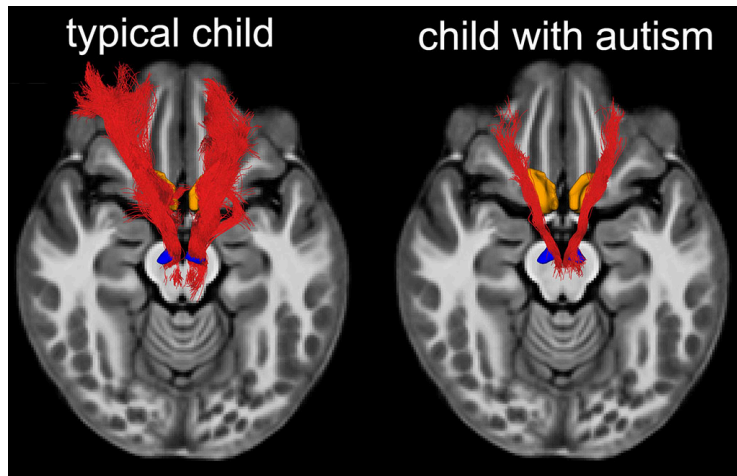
MRI scans reveal that kids with autism contain deficits in a brain pathway that makes social interactions feel rewarding. (Digitale)
